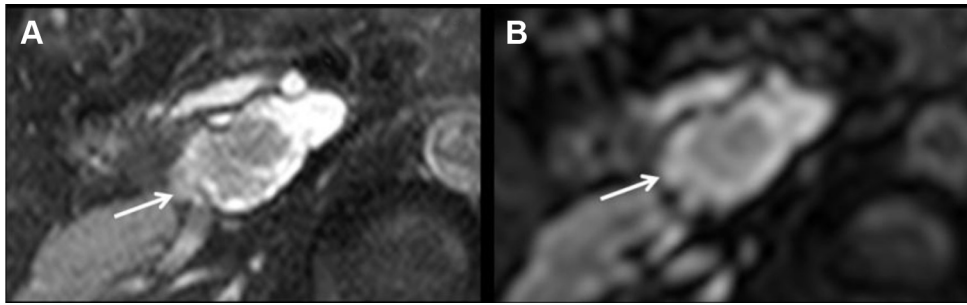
Noncontrast magnetic resonance imaging of the abdomen. (A) The mass (arrow) shows hyperintensity on T2-weighted imaging. (B) Diffusion-weighted imaging shows high signal intensity in association with low apparent diffusion coefficient values, indicating the mass (arrow) is likely to be IPMN with high-risk stigmata.
